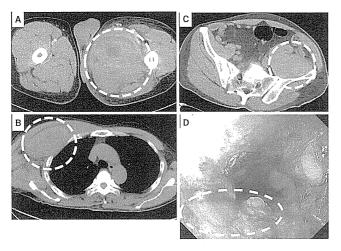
Computed tomographic images and an endoscopic picture. a Left femoral hematoma at first visit (Jan. 201X + 1). b Right axillar hematoma at first visit (Jan. 201X + 1). c Retro-peritoneal hematoma
